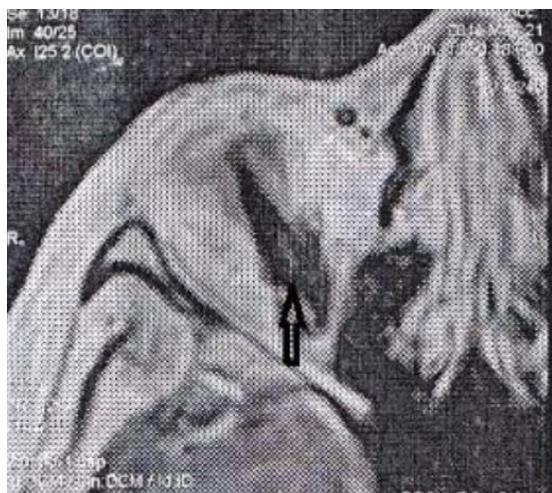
Axial T1WI MRI showing the intraorbital foreign body (black arrow) (Turliuc *et al.*, 2015a).
